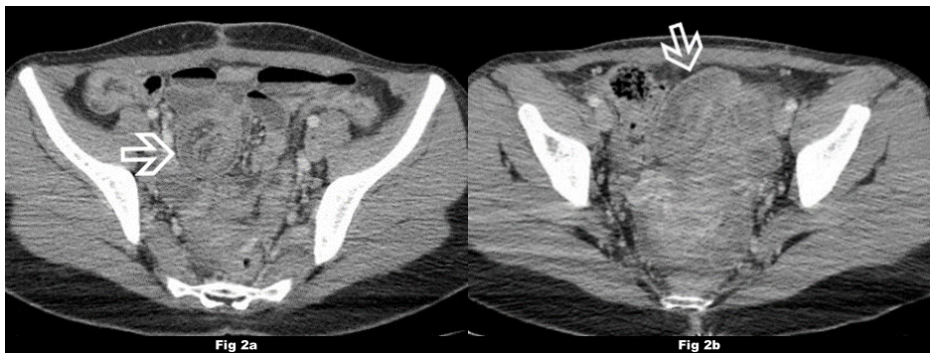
a,b. Patient with ileo-ileal intussusception. Axial CT images show the proximal segment of the ileum is telescoping within the lumen of the distal ileal segment. (a) “Target” sign (b) “pseudo-kidney” sign (hollow arrows).
